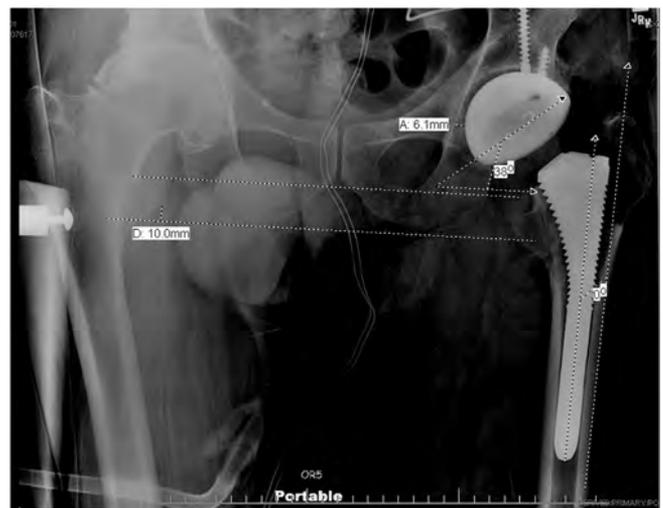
Example of measurements made on intraoperative radiographs: acetabular cup inclination (38°), femoral varus/valgus (0°), distance from Kohler's line to acetabulum (cup medialization) (6.1 mm), leg length difference (10 mm), and cup seating (incomplete) screw position (intra-osseous).
